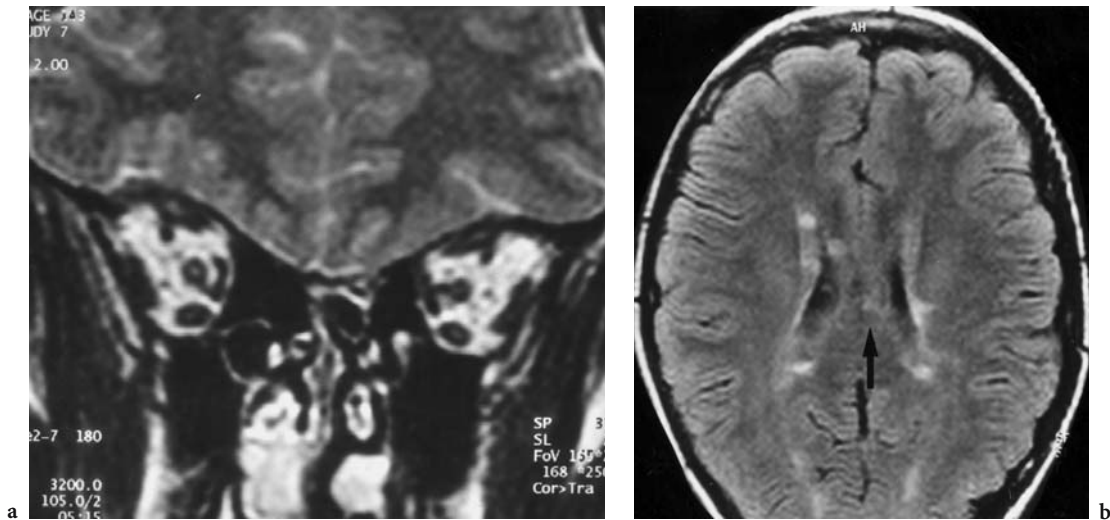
A 13-year-old girl with first occurrence of acute right loss of vision with typical signs of retrobulbar neuritis. Diagnosis: multiple sclerosis. MRI: a Coronal T2-weighted image with distinct intraoptic signal enhancement of the right optic nerve. b Axial T2-weighted FLAIR-sequence of the intracranial parenchyma at the level of the sella media, demonstrating typical changes associated with multiple sclerosis as paraventricular and intracallosal (*arrow*) signal enhancement
